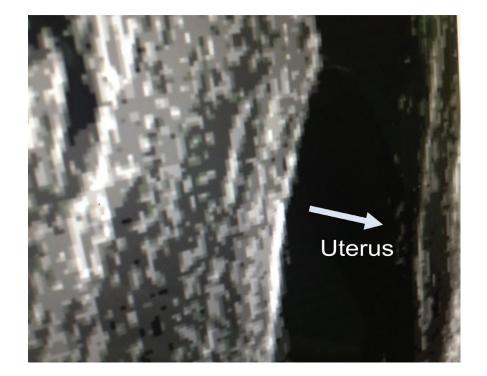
A Sagittal view of a pelvic ultrasound of a newborn female baby with ambiguous genitalia caused by congenital adrenal hyperplasia, due to 21 hydroxylase deficiency showing a uterus (Ut) with echogenic endometrium.
